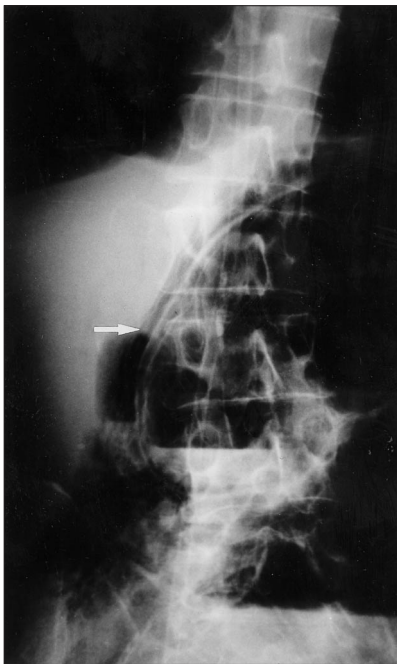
Enlargement of the abdominal X-ray shown in Figure 1 demonstrating gas in the caecal wall (arrow).
